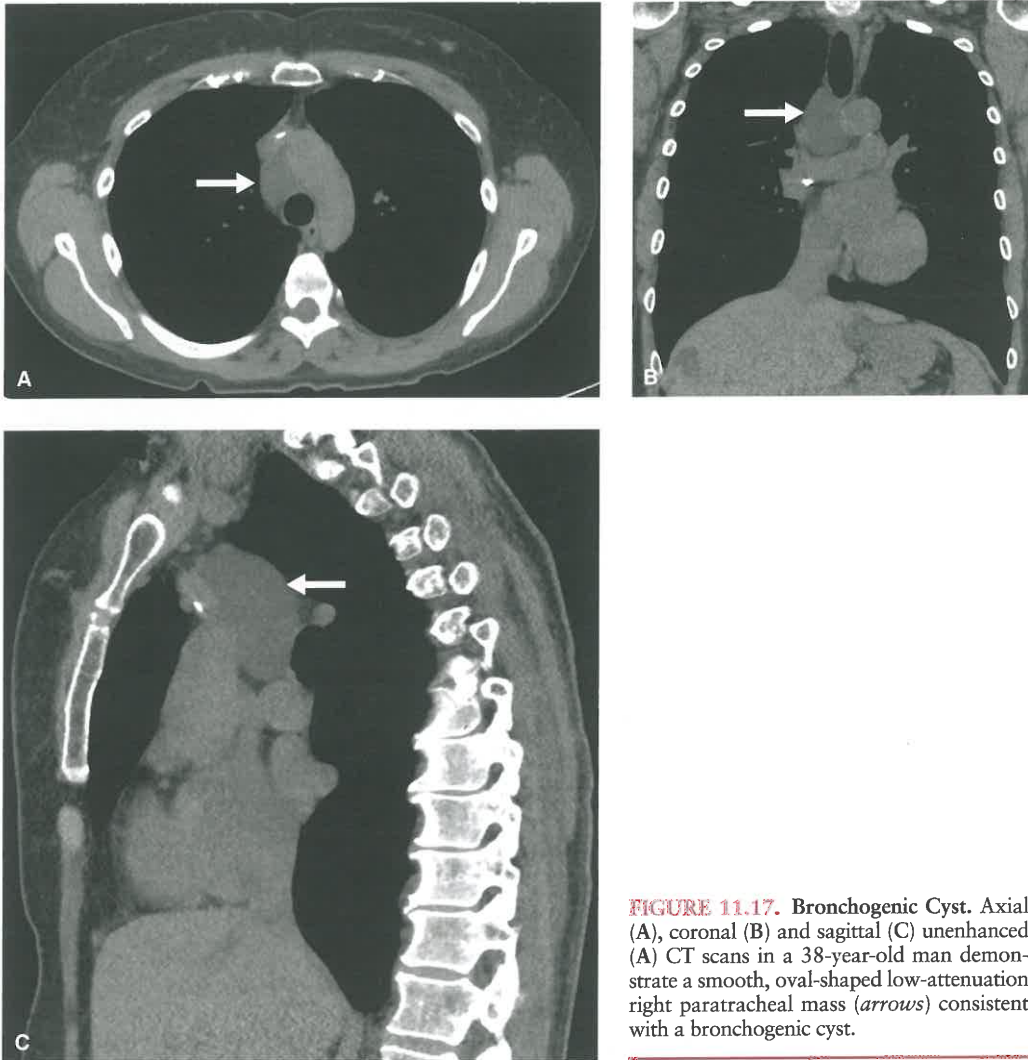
Bronchogenic Cyst. Axial (A), coronal (B) and sagittal (C) unenhanced (A) CT scans in a 38-year-old man demonstrate a smooth, oval-shaped low-attenuation right paratracheal mass (arrows) consistent with a bronchogenic cyst.
